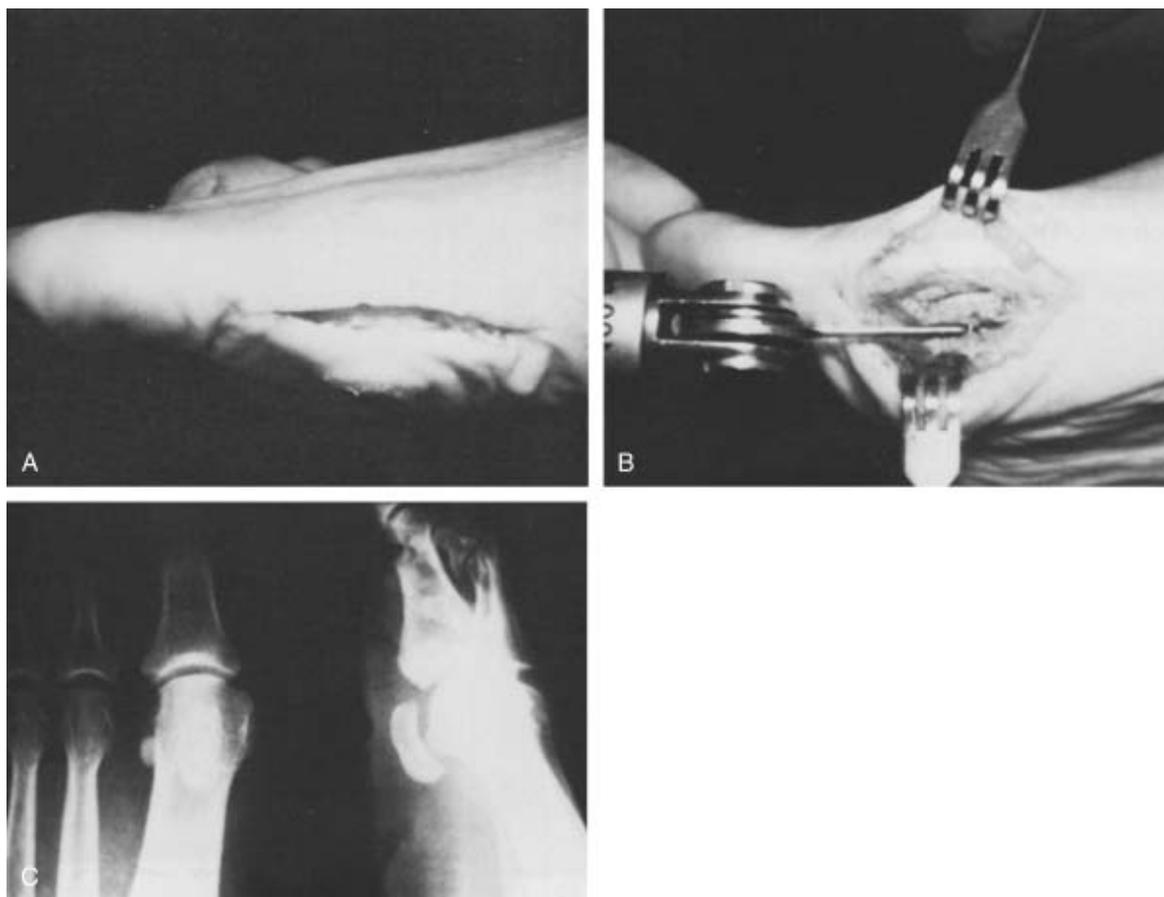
40 A, A plantar medial incision is used to expose the medial sesamoid for shaving. B, Half of the tibial sesamoid is shaved to treat an intractable plantar keratosis. Care is taken to protect the flexor hallucis longus tendon. C, Radiograph after tibial shaving. (© M. J. Coughlin. Used by permission.)
